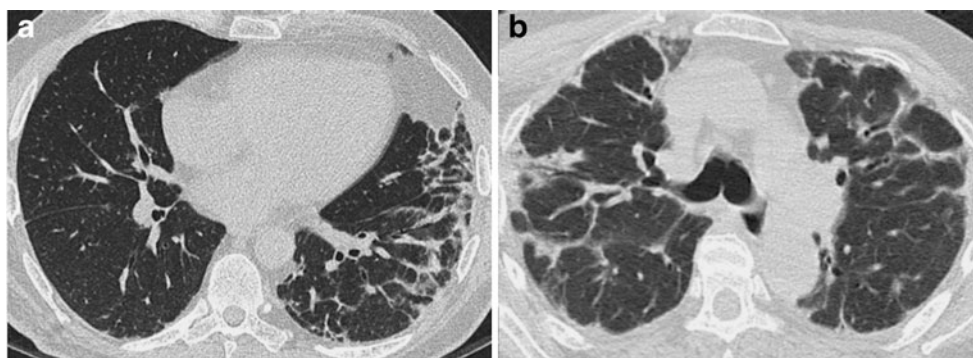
Peribular pattern. a. A 47-year-old man developed breathlessness, cough and malaise over 2 months. HRCT image through the lower lobes demonstrated arcade-like curvilinear opacities forming irregular polygons. Identification of this peribular pattern led to a diagnosis of organizing pneumonia and the patient responded
